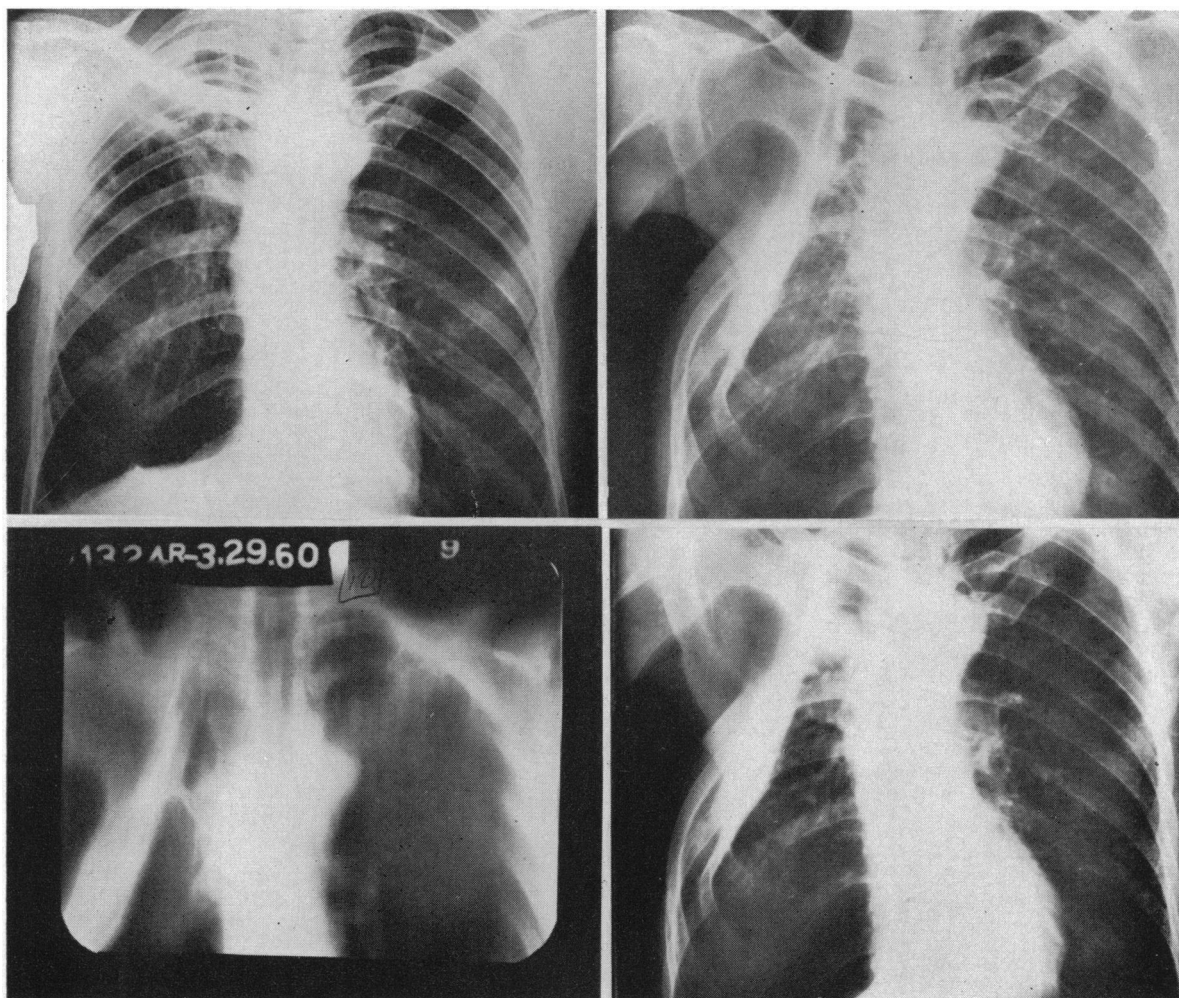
(Case 1). Picture at upper left, right apical tuberculous cavity for which thoracoplasty was performed in 1957. In the picture at upper right, cavity still present beneath right thoracoplasty. At lower left, the cavity is seen better on a planigram. In roentgenogram at lower right, the cavity is no longer seen after bronchial division. The aerated area beneath the thoracoplasty is emphysematous lung tissue.
